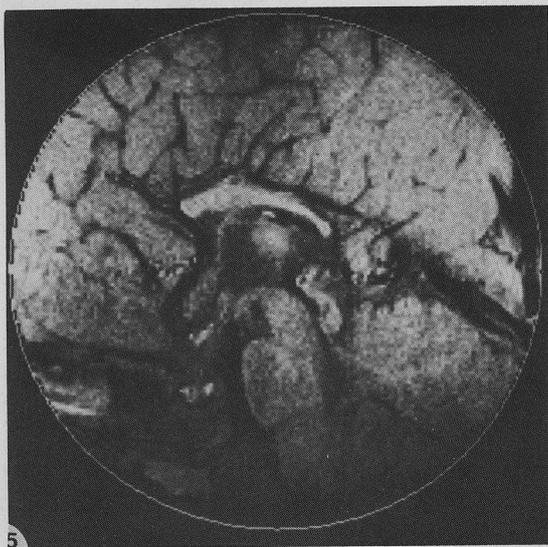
Hypoplasia of the corpus callosum with absent genu and thin, small splenium. MRI-T1-weighted sagittal section, case 7.
